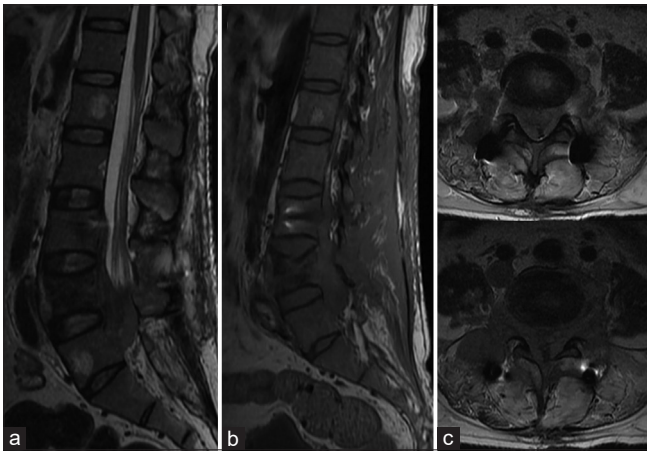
(a-c) Sagittal T2, Sagittal T1 and axial T2 weighted magnetic resonance imaging respectively at the end of one month following initial surgery showing increase in the lesion and wide involvement of the L4 body and extension of the lesion into the spinal canal
